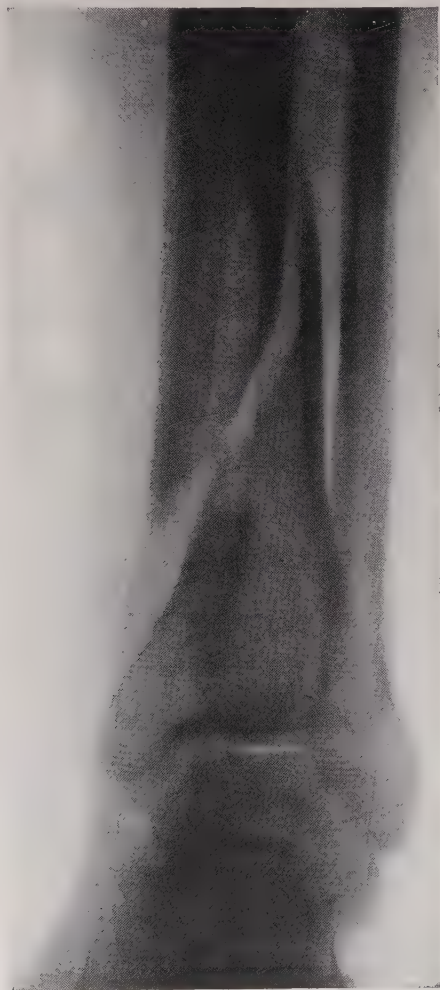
Spiral fracture of the tibia from torsion strain. This type of fracture is practically always associated with fracture of the fibula in the upper third, and this feature of the injury is frequently overlooked because the roentgenogram does not include the entire leg. (Fracture Service, M. G. H.)
